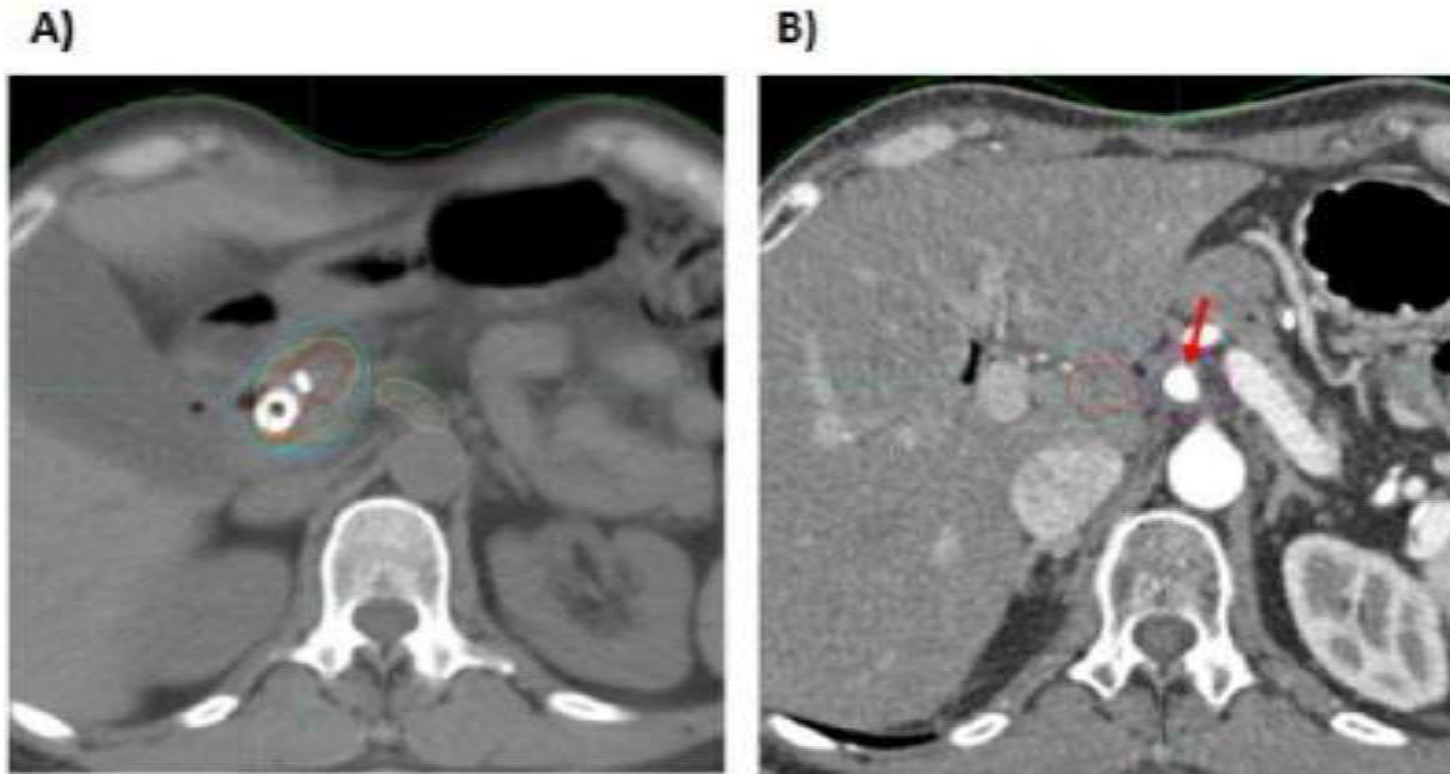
(A) Patient with borderline resectable tumor due to SMV encasement treated to the primary tumor alone. A local-only recurrence occurred at the SMA 7 months from surgery as the first site of failure. (B) CT at time of recurrence fused to planning CT revealing the recurrence volume marginal to the original PTV (arrow).
